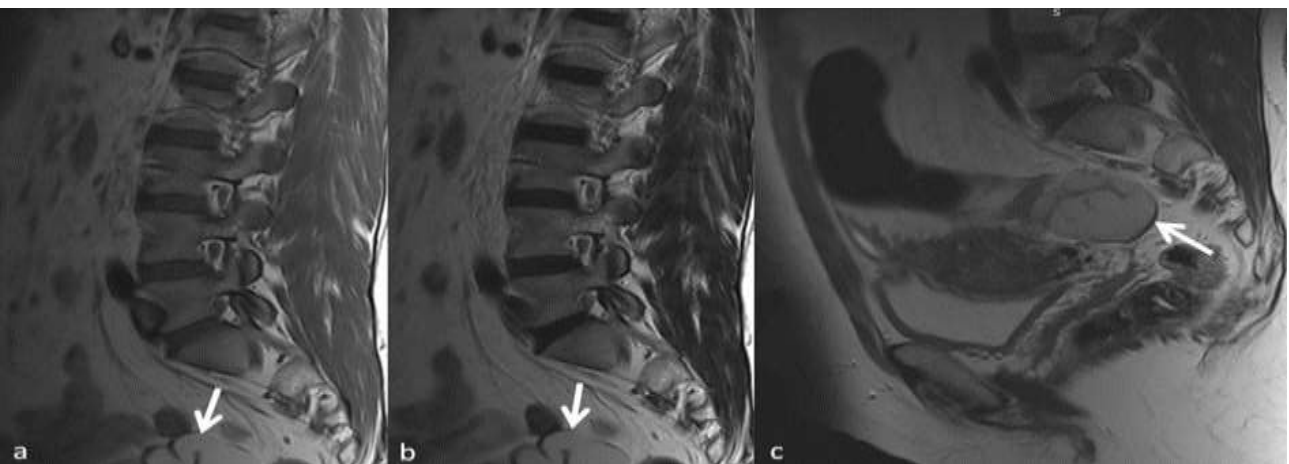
Hyperintense tortuous tubular structures in sagittal T1A (a) and T2A lumbar MR images of a 45 year old female patient with low back pain. Lumbar MRI will not reveal pain herniation or degeneration findings. In the pelvic MRI taken on the passage of pain, (c) both tubs are full of dilate, tortuosity and blood.
